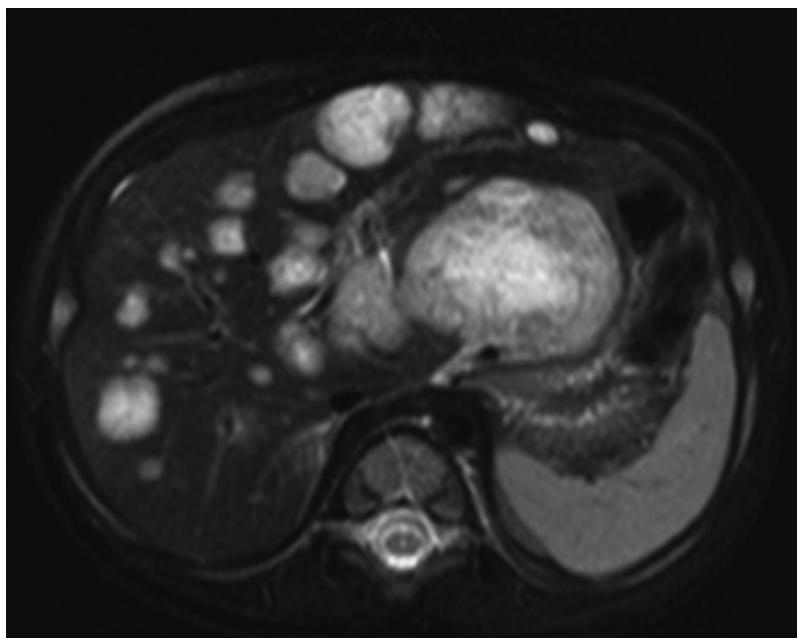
An abdominal magnetic resonance imaging of a 2-month-old child with stage 4S neuroblastoma demonstrating extensive, multifocal liver involvement.
